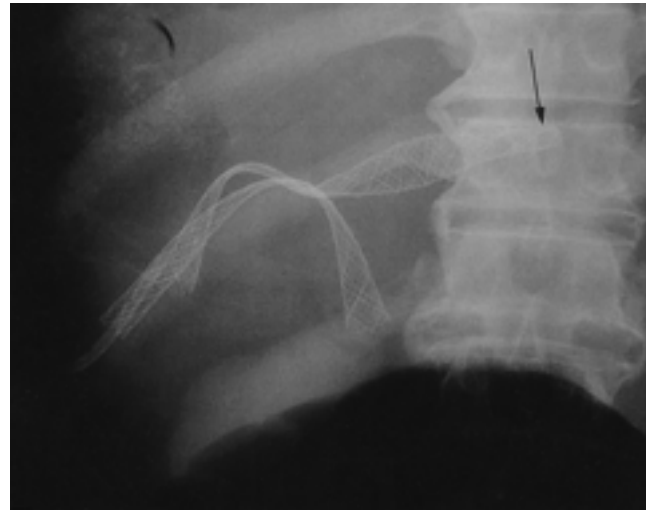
Poor expansion of stents without balloon dilatation. Simple radiograph shows poor self-expansion of X-shaped stents in the crossing portion within the mass. The interlobar stent is partly dwelling in left lobe of liver along insertion route (black arrow).
